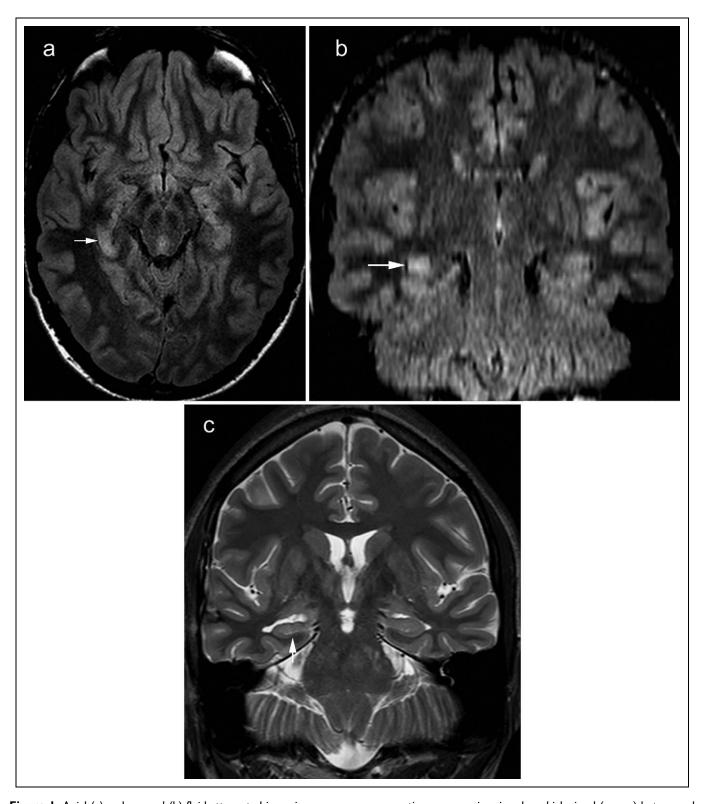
Axial (a) and coronal (b) fluid-attenuated inversion recovery on magnetic resonance imaging show high signal (arrow) but normal volume of the right hippocampus. (c) Coronal T2 at 3 months after discharge shows atrophy (arrow) of the right hippocampus.
